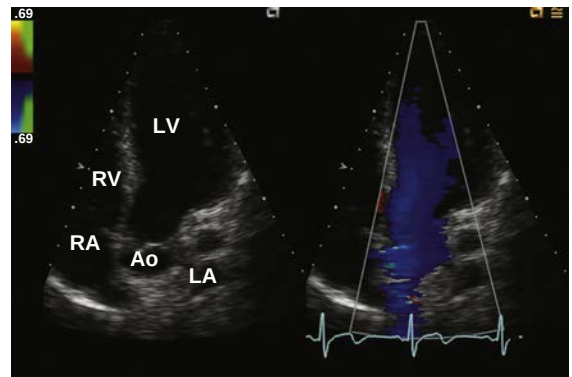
Anteriorly angulated apical 4-chamber view (or 5-chamber view). Anterior angulation from the 4-chamber view allows visualization of the LV outflow tract and an oblique view of the aortic (Ao) valve. Laminar flow in the LV outflow tract is demonstrated with color Doppler.
